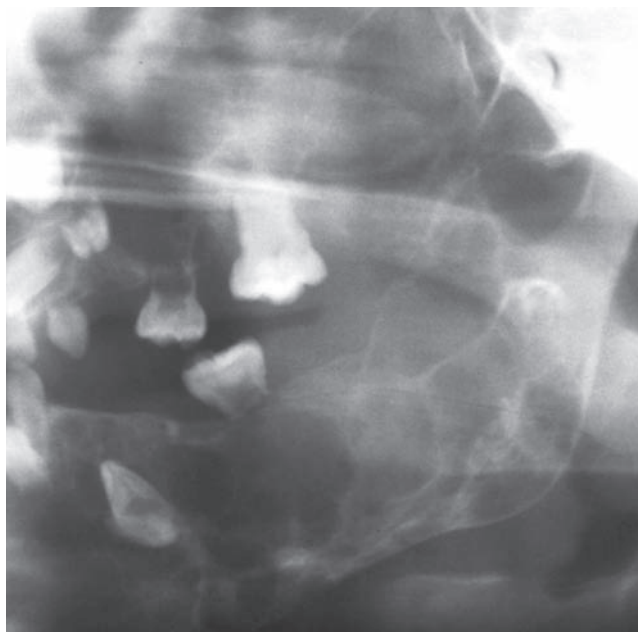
Multilocular. The multilocular radiolucent lesions in this radiograph are associated with a connective tissue condition called cherubism.
